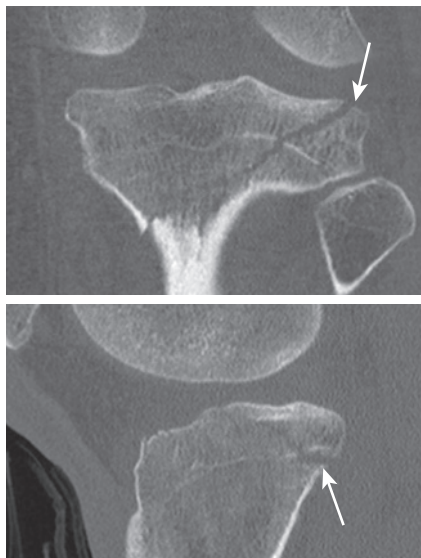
Coronal and sagittal reconstruction from a computed tomogram of the knee demonstrating a non-displaced fracture of the lateral tibial plateau (*long arrows*).
